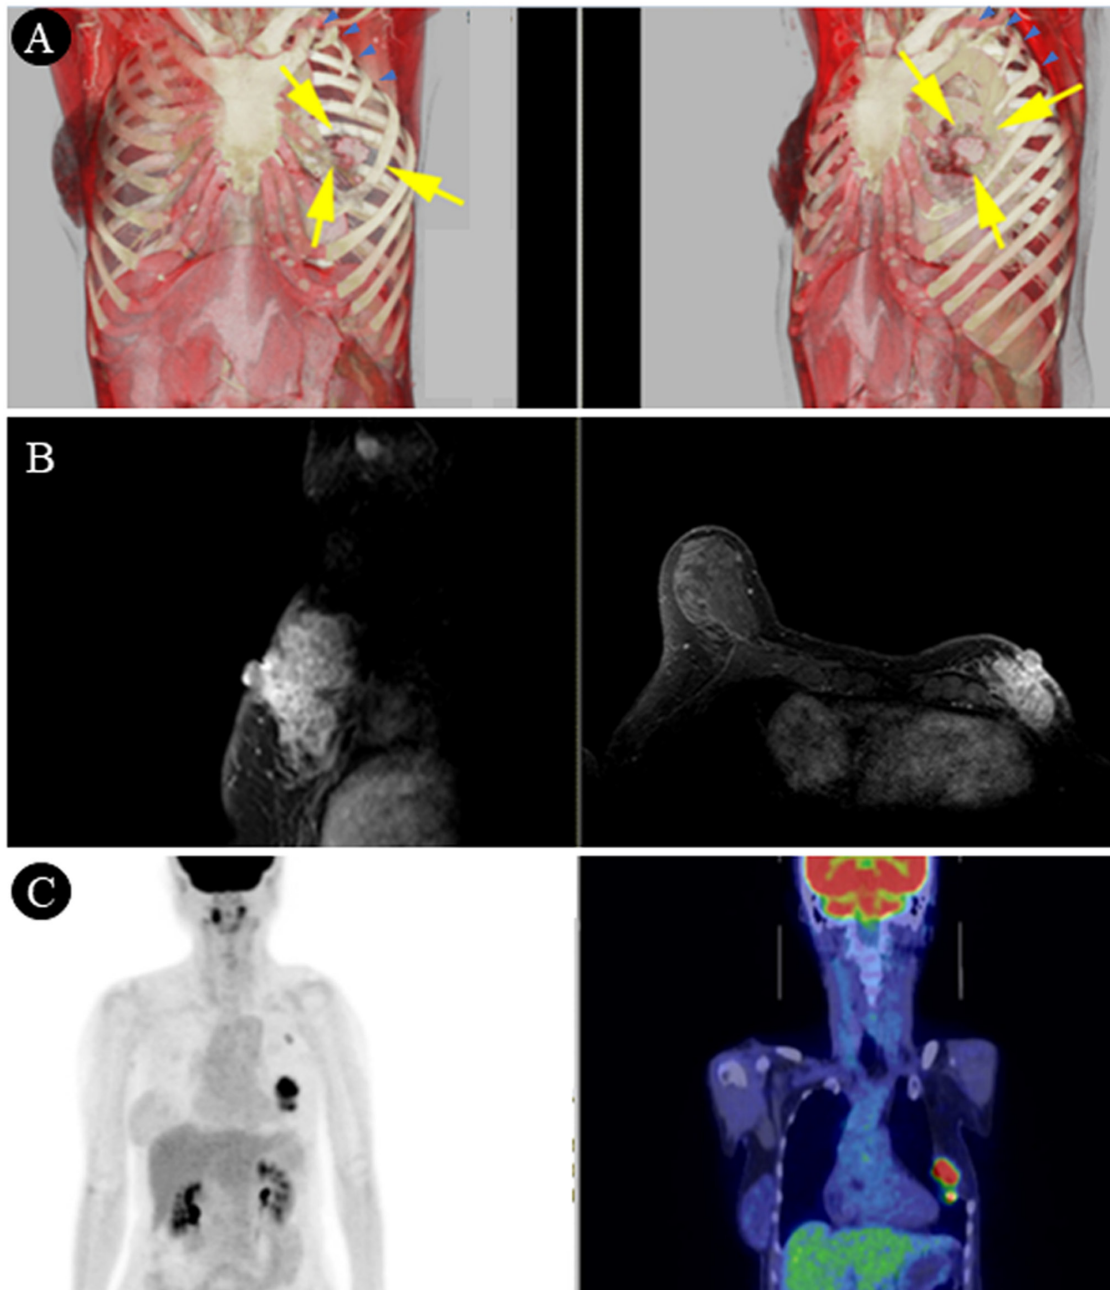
CT, contrast-enhanced MRI and ¹⁸F fluorodeoxyglucose PET images. (A) Preoperative three-dimensional CT (volume-rendering imaging) image showing hypoplasia of the left chest wall (arrow: pectoralis major; arrowhead: ribs 2-5). (B) MRI image of breast cancer in the left anterior-central region. (C) PET/CT images before surgery. No distant metastases other than the primary tumor and axillary lymph node metastasis is evident. PET, positron emission tomography; CT, computed tomography; MRI, magnetic resonance image.
